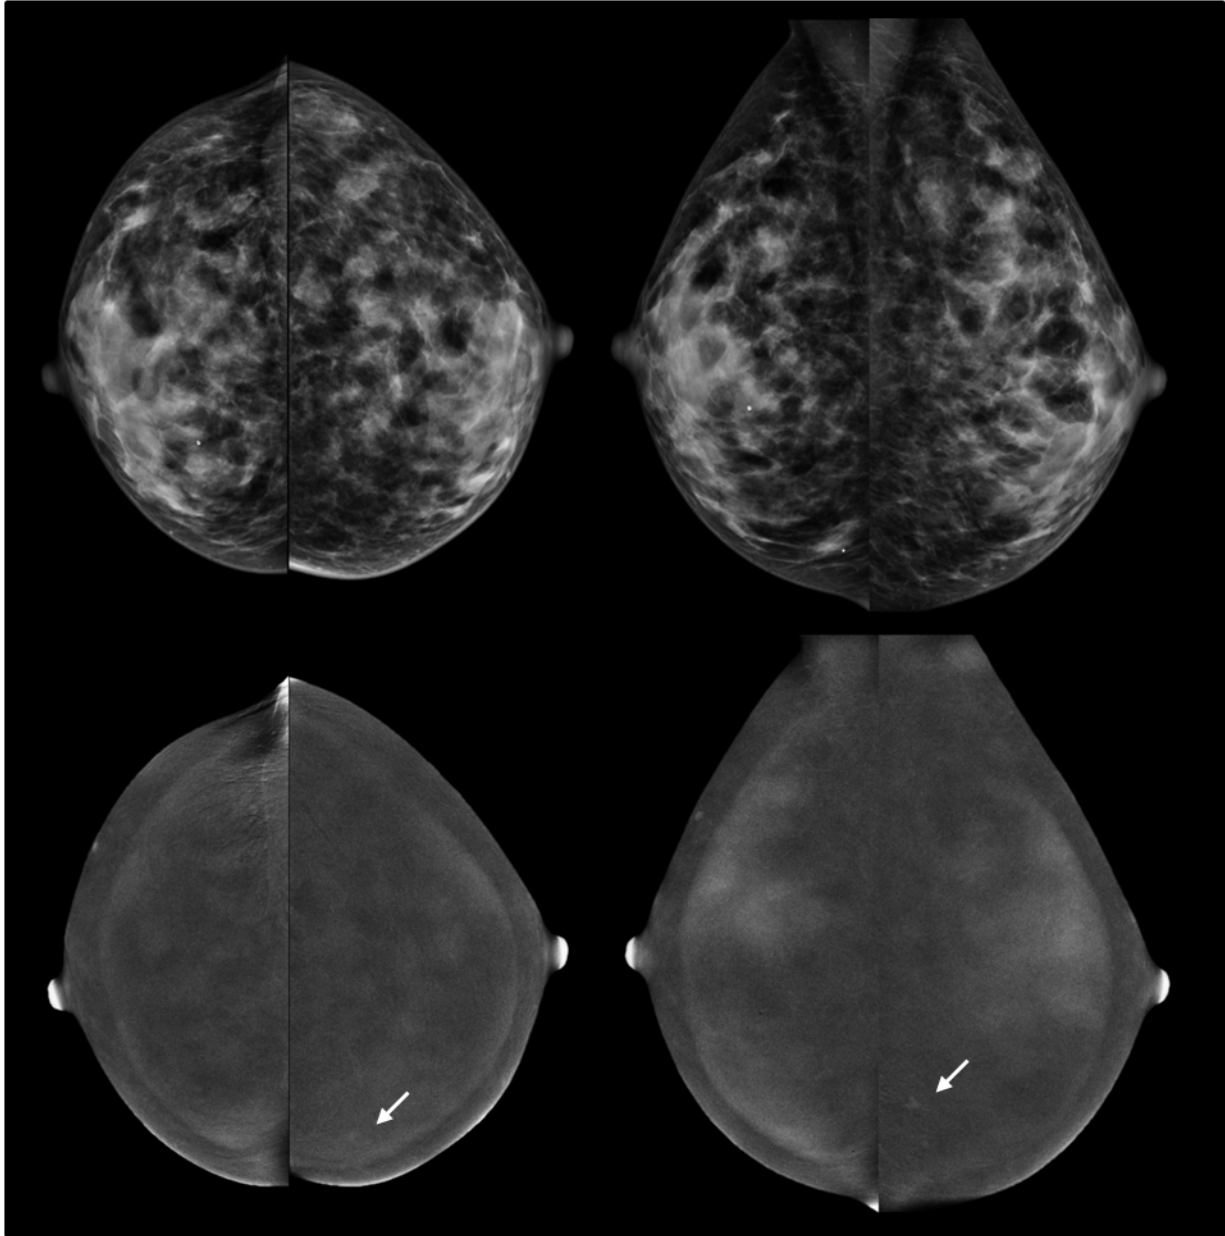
56-year-old woman with heterogeneously dense breasts on standard mammography (upper images) and moderate risk of breast cancer. Screening CEDM (lower images) shows focal enhancement in the left breast at 8 o'clock (arrow). The finding was identified on ultrasound, and US-guided biopsy showed invasive ductal carcinoma. Note the background parenchymal enhancement, analogous to that seen in contrast-enhanced MRI. *Images courtesy of Jennifer Harvey, MD.*
